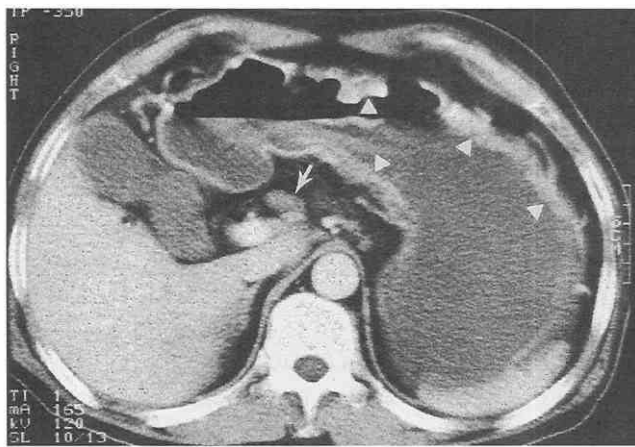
Gastric fold thickening due to gastrinoma. CT scan shows marked gastric distention and fluid excess with prominent and thickened mucosal folds (*arrowheads*). A small mass (*arrow*), which was confirmed as gastrinoma at surgery, is noted in the perigastric region.
